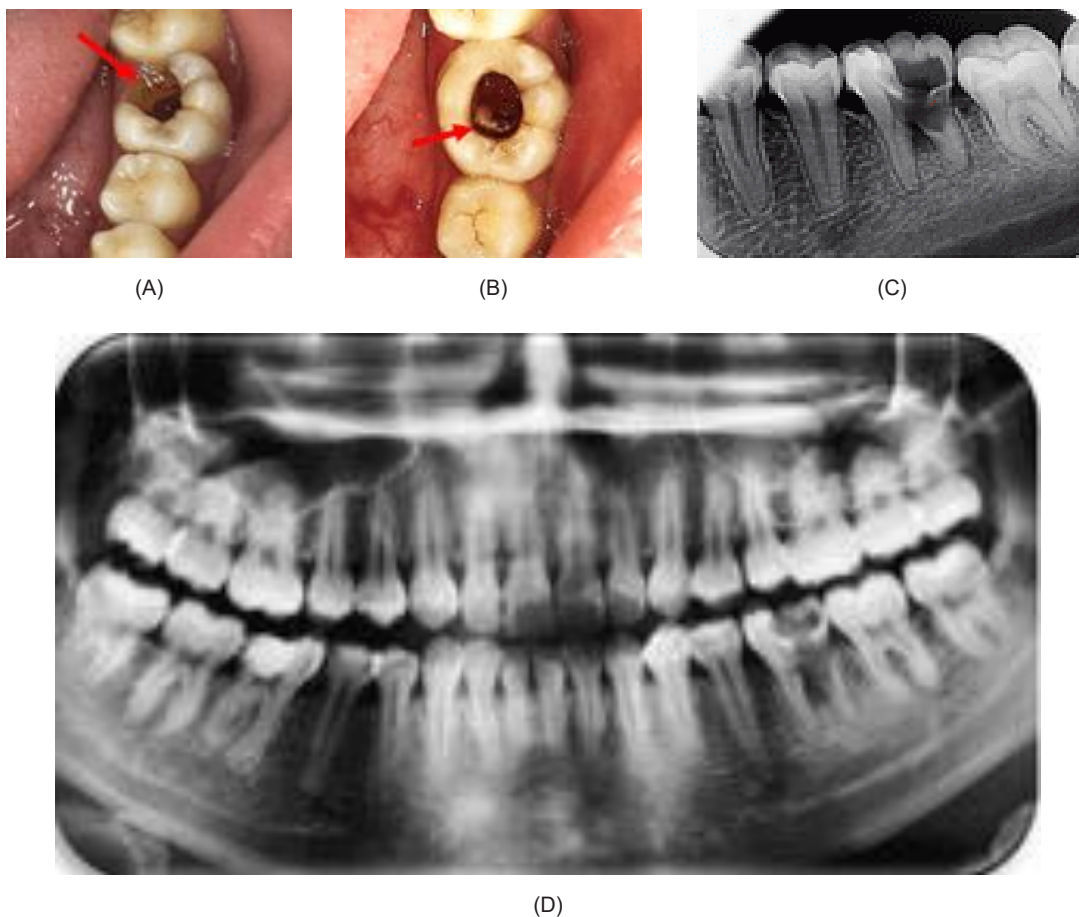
Clinical and radiographic features of tooth 36 before treatment: (A) Cavity at the distolingual part and perforation at the distal bifurcation (arrow). (B) At the perforation, there was granulation tissue covering the base of the distal root pulp chamber, and the base of the mesial root pulp chamber and its orifice were visible (arrow). (C) Periapical radiographic image of tooth 36 before treatment. (D) Panoramic radiographic image before treatment. A radiolucent image was visible on the crown of tooth 36 reaching the pulp and bifurcation area and there was widening of the periodontal ligament space at the distal root of tooth 36.
